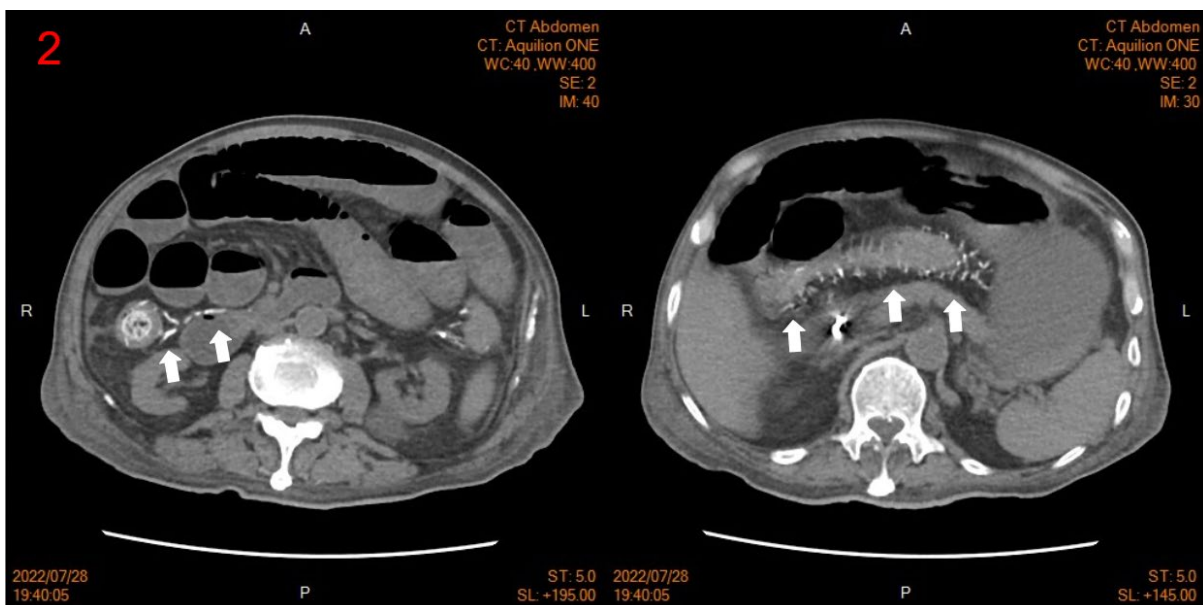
Abdominal CT revealed typical finding of threadlike calcification of colonic veins over a scending and transverse colons.(white arrows)
